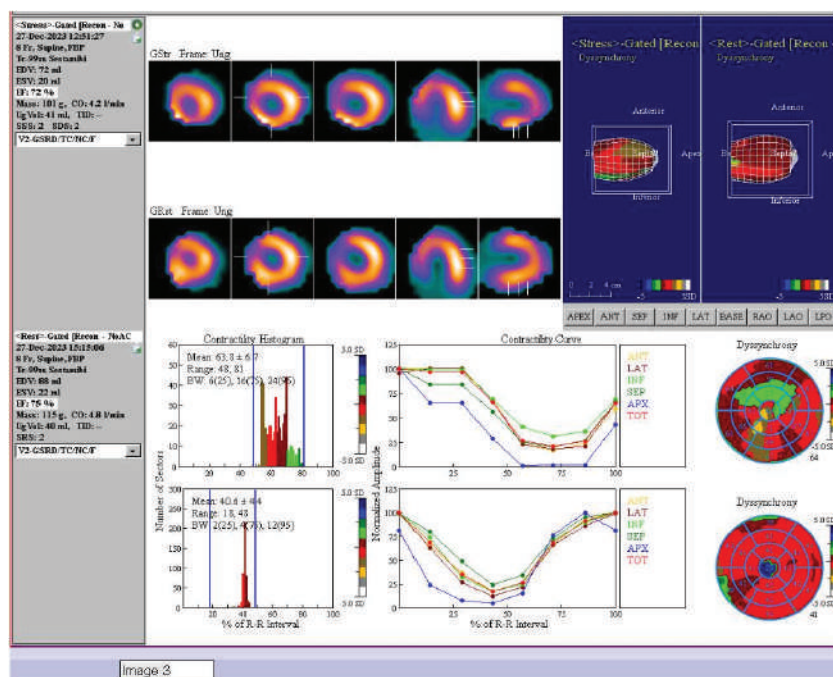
^{99m}Tc sestamibi gated SPECT Myocardial perfusion scan image showing myocardial contractility curve. The curve shows normal contracted walls, EF, EDV, and ESV.
